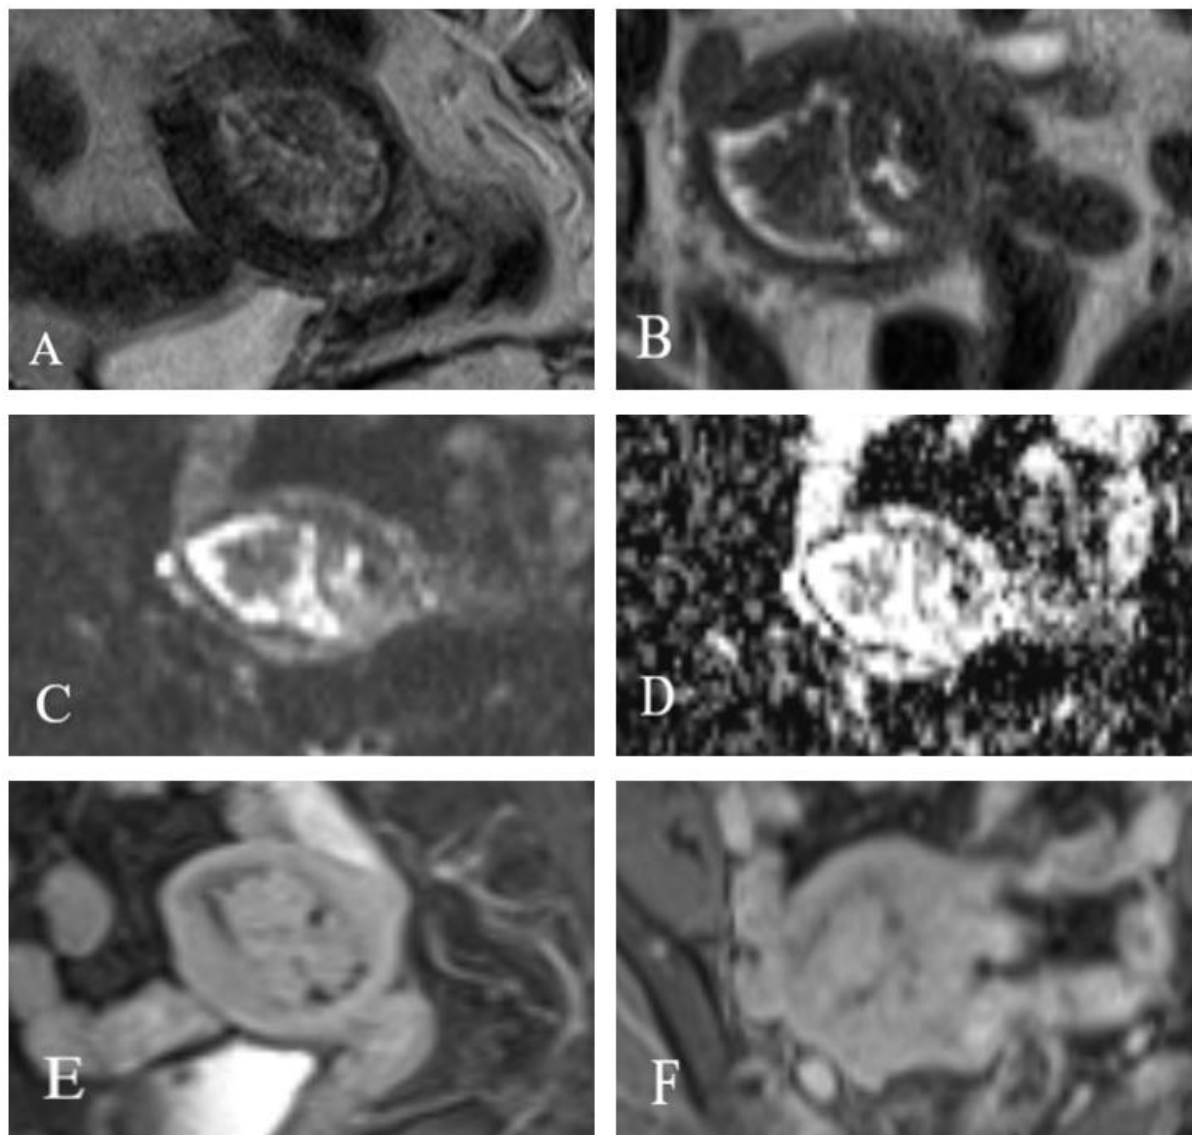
A 53 - year - old female with endometrial carcinoma. T2 weighted images (A) Sagittal and (B) Coronal sections shows a heterogeneously hyperintense polypoidal endometrial lesion with few papillary projection along the periphery. (C) DWI and (D) ADC shows no significant diffusion. (E) and (F) represent T1 weighted Post - Contrast images showing mild heterogenous enhancement.
